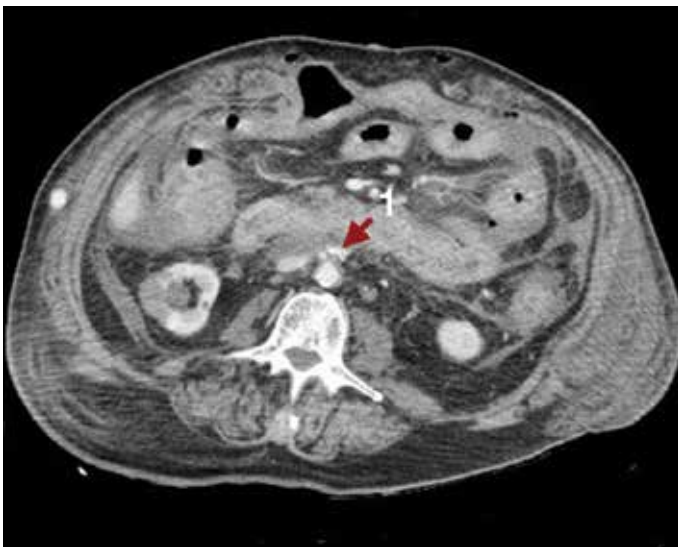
CT abdominal scan with extravasation of IV contrast (1) in relation to active bleeding around the surgical drainage catheter
